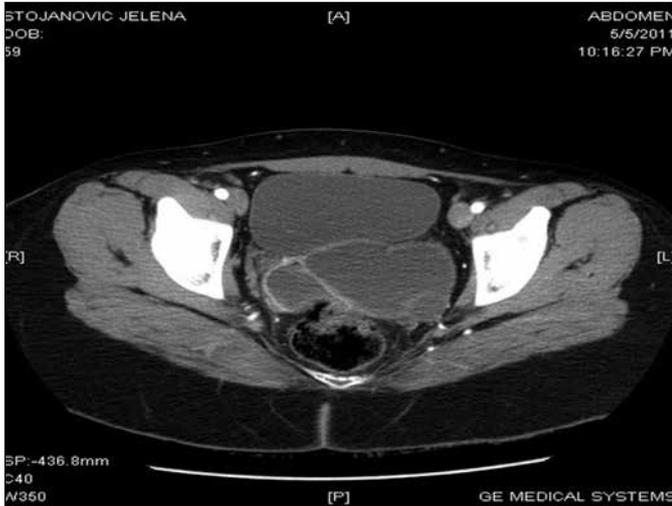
CT showing pseudocystic formation on the left and beneath the urinary bladder.
